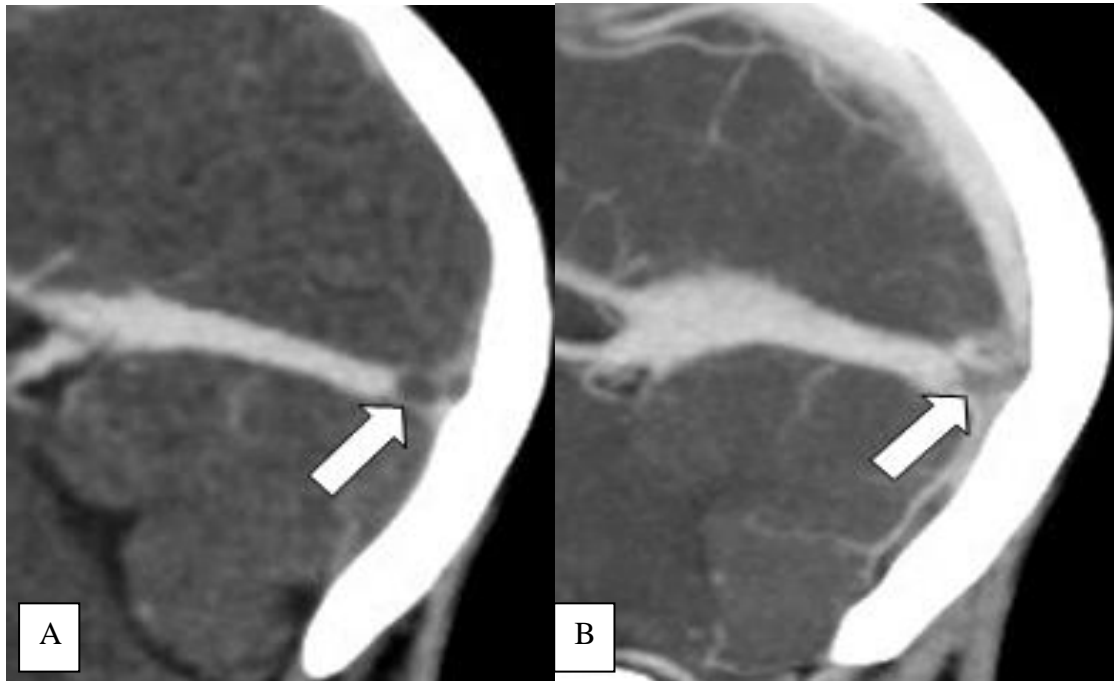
Sagittale MPR reconstruction of an injected brain CT showing a thrombus on the torcular (arrow A). The thin MIP reconstruction shows a defect within the venous sinuse (arrow B). Notice that the thrombus is worse defined than on MPR image on B.
